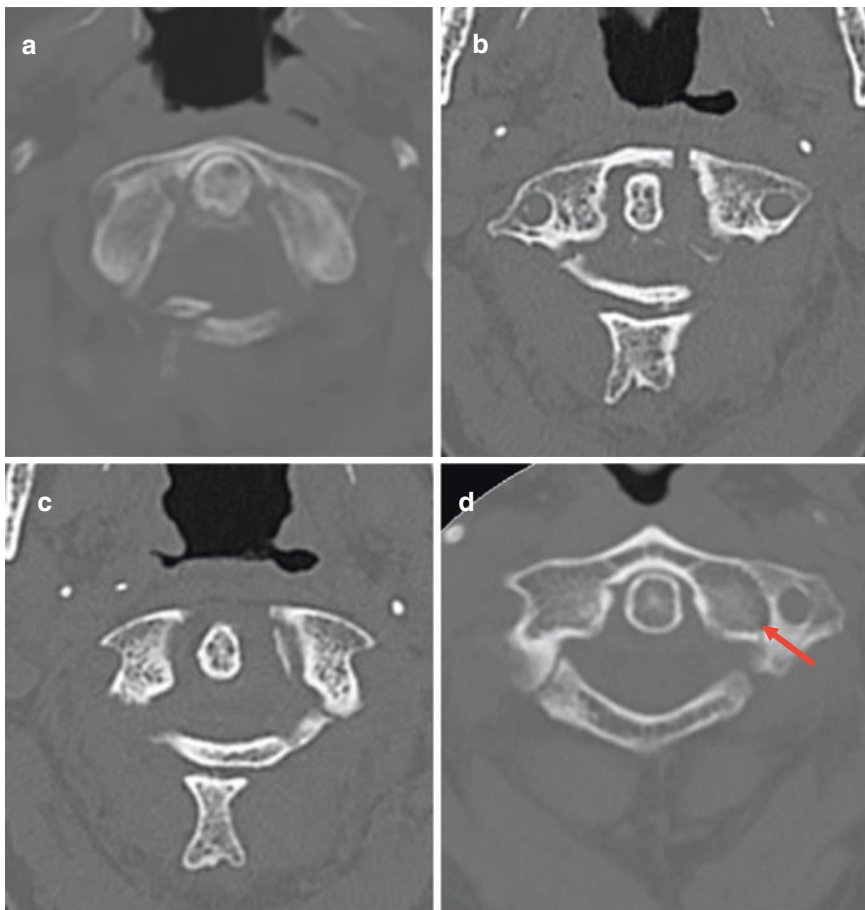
Fractures of the atlas according to the Landells classification as shown on axial cervical spine CT imaging. (a) Type I C1 fracture of the posterior arch only. (b, c) Type II fracture involving the anterior and posterior arches of the atlas. (d) Type III fracture showing extension into the left C1 lateral mass (red arrow)
